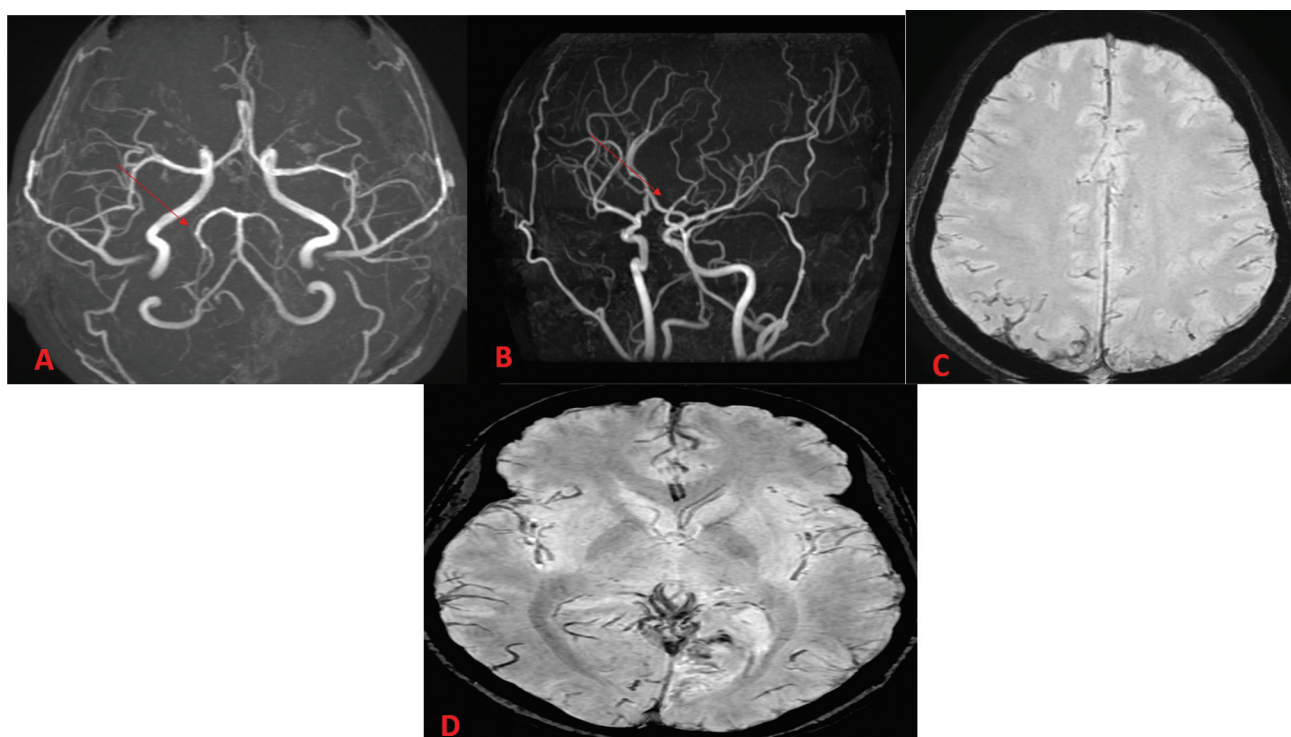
Follow-up magnetic resonance imaging brain was done after 3 months of initial presentation. Time-of-flight magnetic resonance angiography circle of Willis (A and B) showing the normal caliber of bilateral posterior cerebral artery (arrow) and distal basilar artery with the disappearance of beading pattern as detected in earlier images at the time of stroke (B and 2D). Susceptibility-weighted imaging (SWI) (C and D) showing the disappearance of convexity SWI blooming foci as compared with old SWI images (B and C) at the time of initial presentation. Diagnosis of reversible cerebral vasoconstriction syndrome was made.
